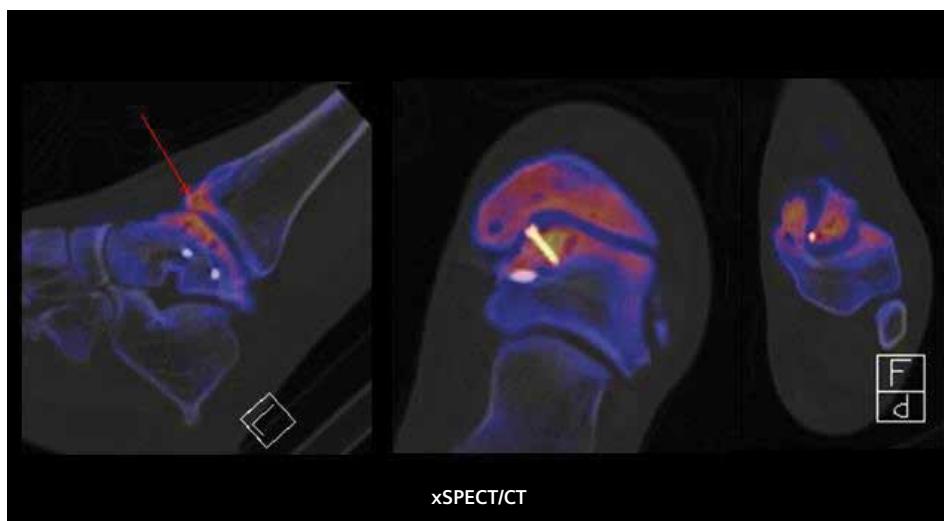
xSPECT Bone and CT fusion images clearly demonstrate the extruded end of the talar fixation screw into the talo-tibial joint space, along with presence of multiple subchondral cysts and skeletal hypermetabolism throughout the articular surface and periarticular bone. Increased uptake in the anterior edge of the tibia (red arrow) with corresponding hypermetabolism in the adjacent talar dome suggests anterior impingement of the edge of the lower end of the tibial shaft, with the anterior talar articular surface, which is probably secondary to irregularities and erosion in the surface of the talar articular cartilage, secondary to impingement and fracture-related distortions.
